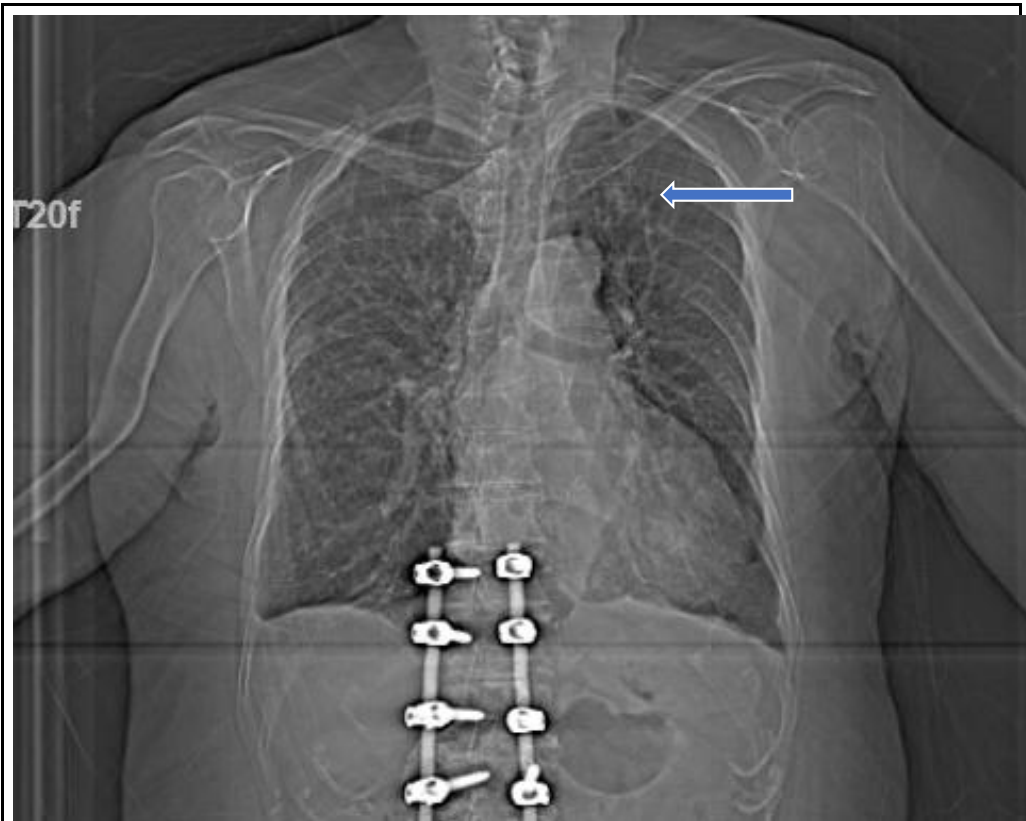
Chest X-ray: Day 1: There is 7 cm mass in the left upper lung field (Arrow)
